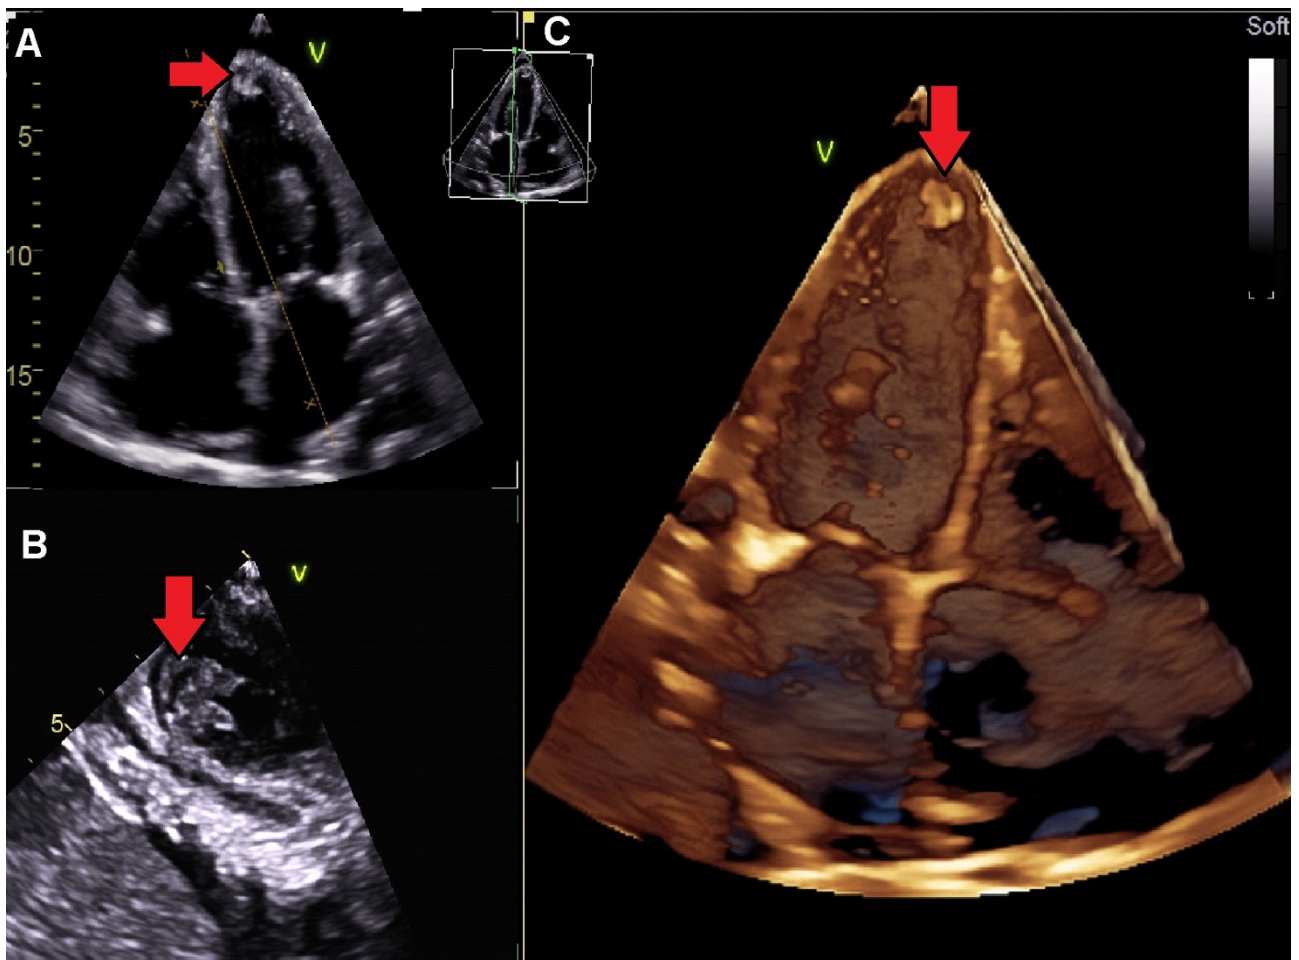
Transthoracic echocardiographic examination in a patient with suspected Transient Ischaemic Attack (TIA) after a previous heart attack involving the apex, with unknown timing: A — Four-chamber apical view. A red arrow indicates an additional structure of variable echogenicity within the area of impaired contractility (apical akinesia with endocardial thinning), corresponding to a thrombus. B — Short-axis parasternal view at the level of the apex. C — Modified three-chamber view, 3D presentation.
